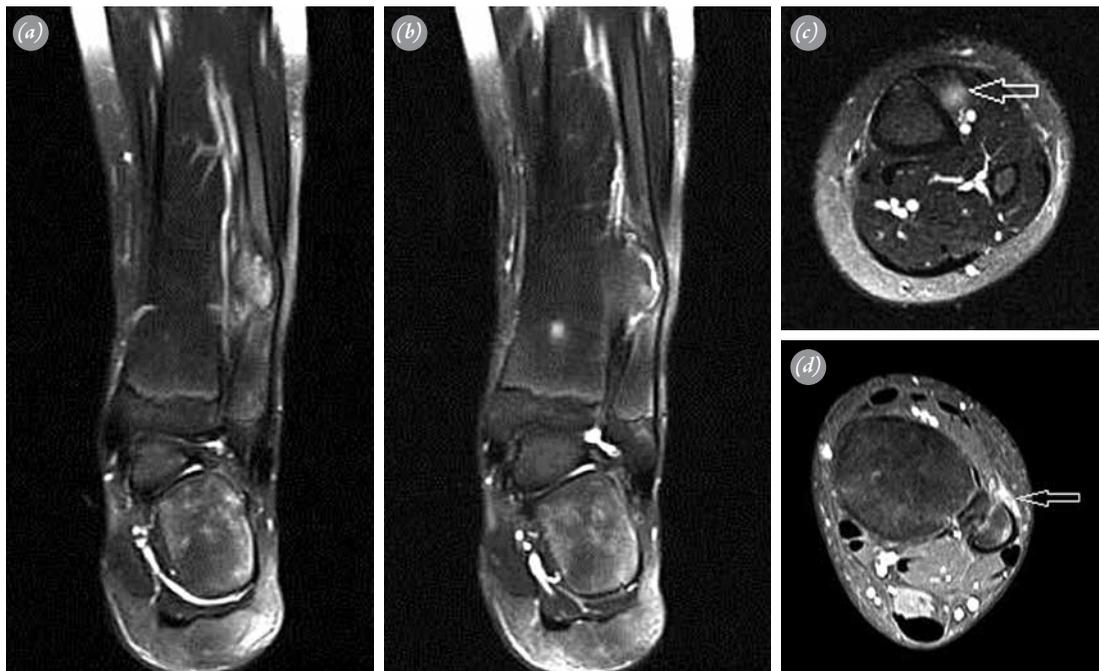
(a) Osteochondroma which makes the fibula stringy, thinner, and deformed is observed on the fat-suppressed, T2-weighted coronal section. (b) The fibula, made springy and pushed laterally by the osteochondroma, is observed on the fat-suppressed, T2-weighted coronal section. (c) The increased signal is observed in the tibialis anterior muscle due to focal edema in sections traversing proximal to the osteochondroma. (d) Contrast uptake is observed at the area indicated by the arrow in fat-suppression, axial, postcontrast sections. Chronic-progressive compression affects the vasa nervorum supplying the nerve and cause contrast uptake by the nerve. The posterior peroneal nerve, normally very difficult to observe, is pushed to the anterolateral and becomes prominent due to contrast uptake (white arrow).
